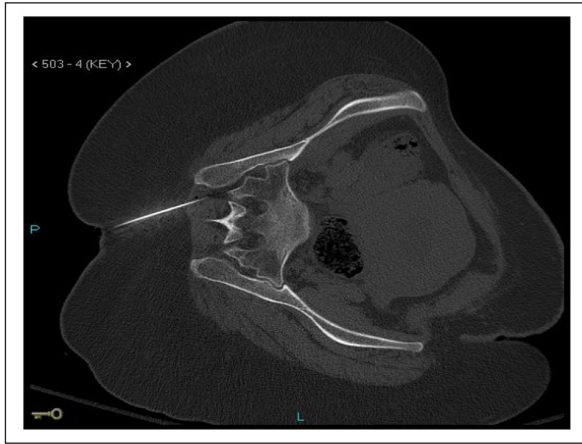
CT-guided right SI joint needle aspiration in the left lateral position.
